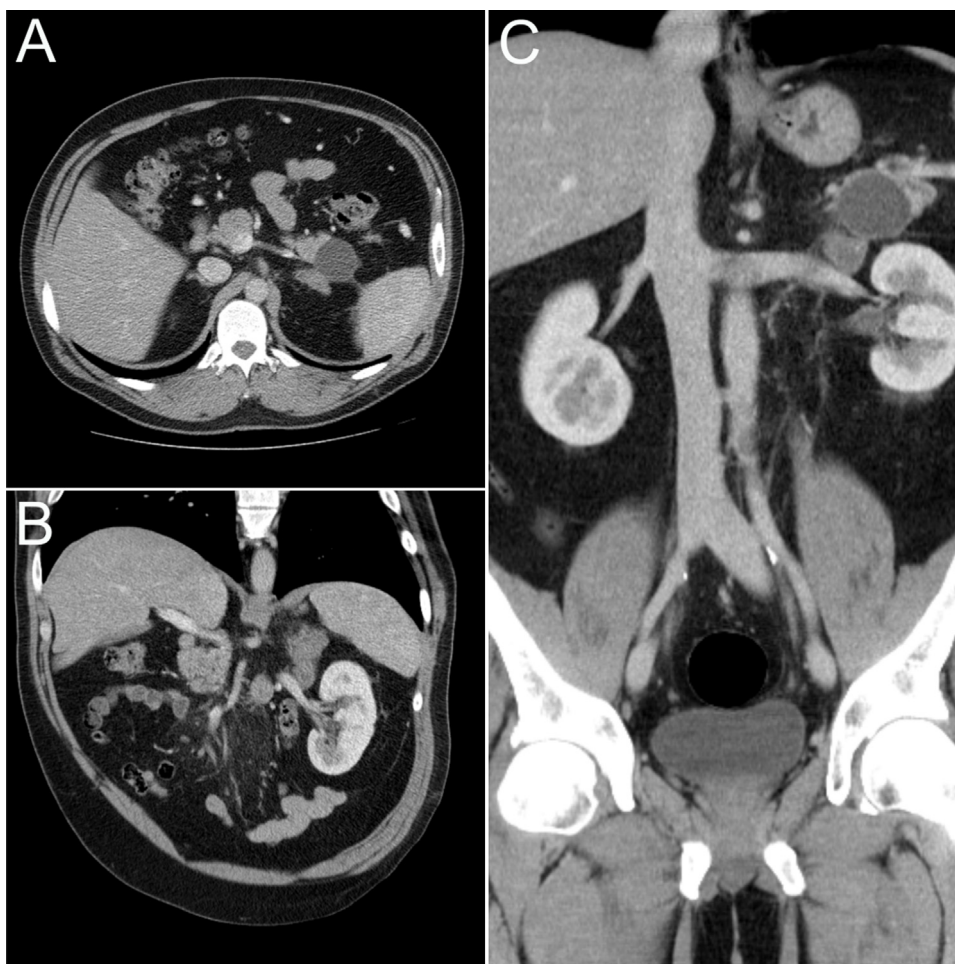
The second disease progression pattern at CT scanning (2012).
